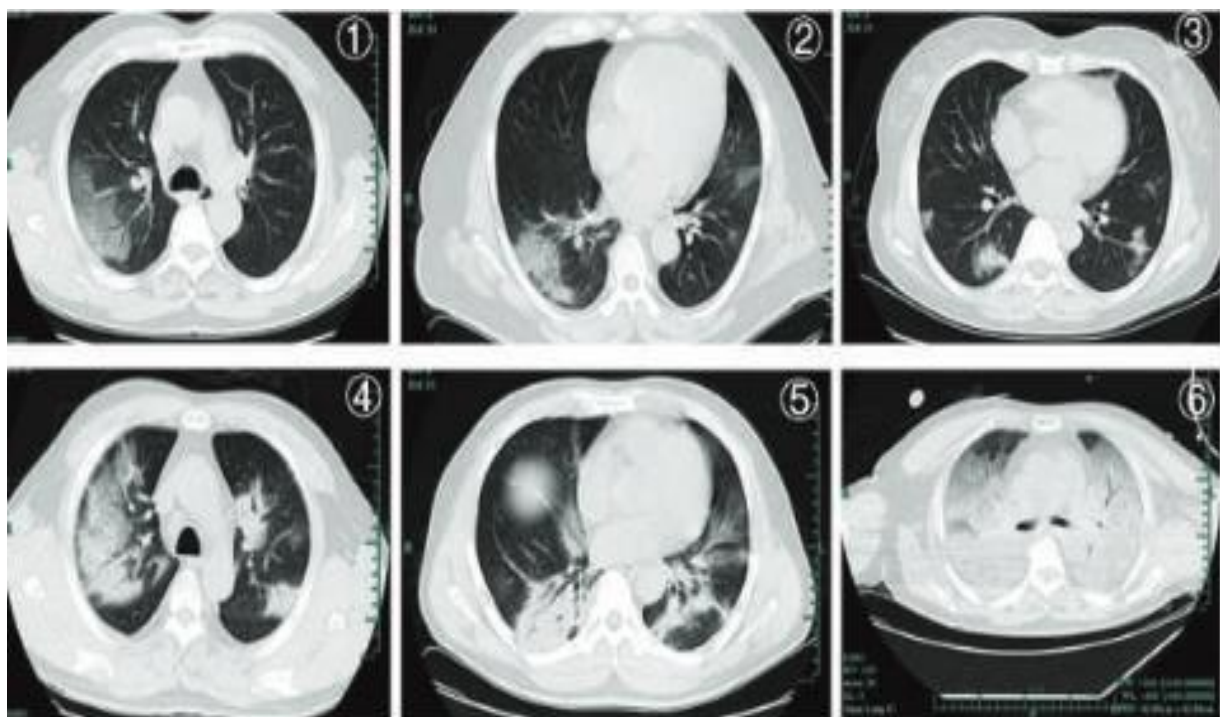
Typical Chest CT signs in patients with coronavirus infection [11].
